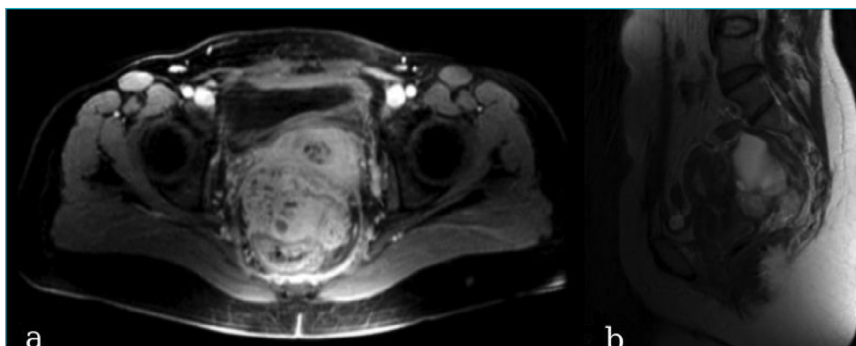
(A) Transverse and (B) sagittal plane of the pelvic magnetic resonance images, respectively. A mass lesion 5x6 cm in diameter with lobulated counter internal small air loculations on the expanded floor of the Douglas pouch.
